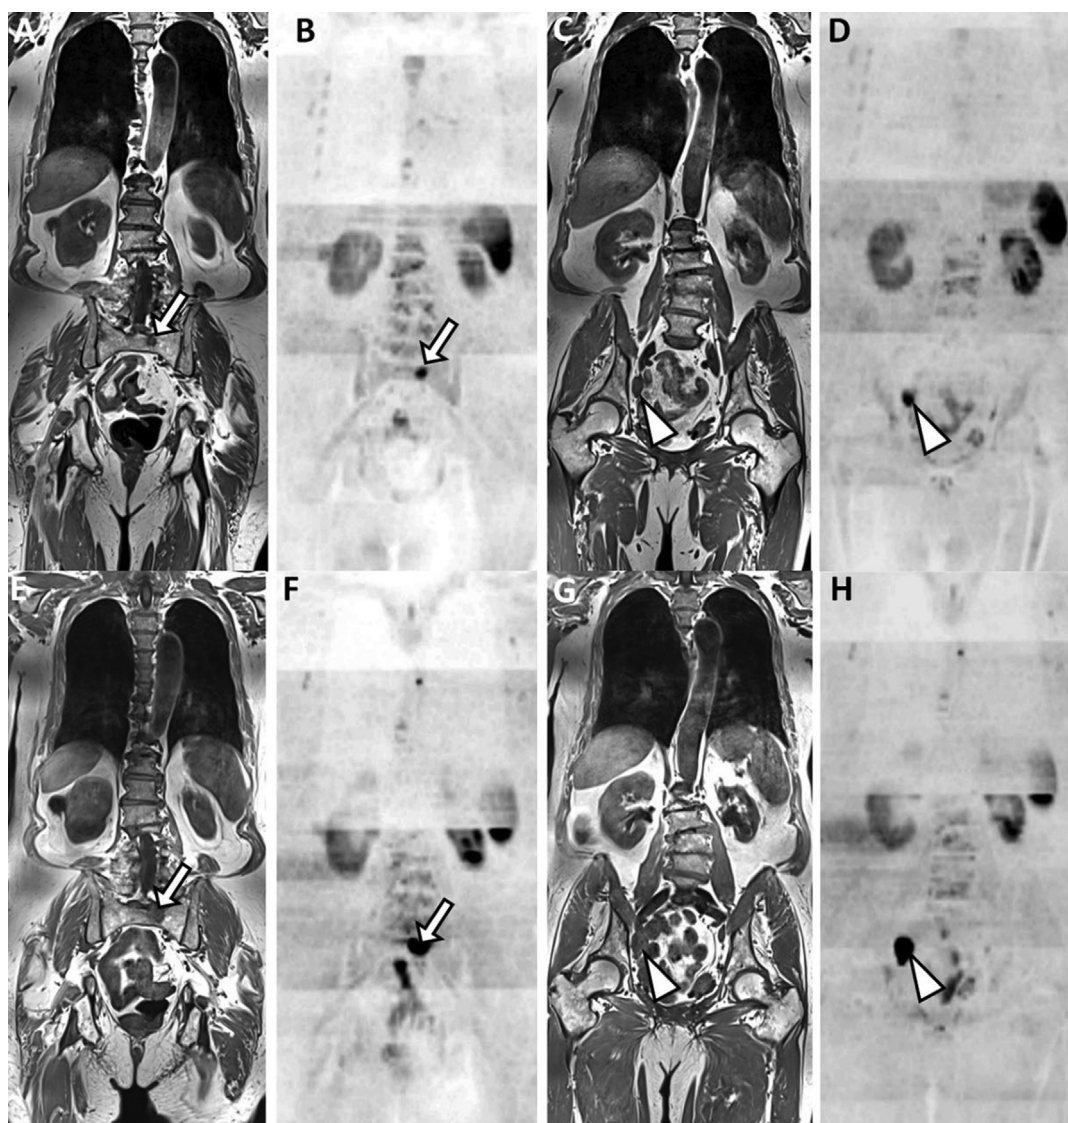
Progression of bone and node metastases in a 77-yr-old man with metastatic hormone-naïve prostate cancer (response assessment category 5). Comparison of whole-body magnetic resonance imaging before and after treatment. (A,C) Coronal T1-weighted images and (B,D) DWI scans ($b = 1000 \text{ s/mm}^2$, inverted gray scale) at baseline show bone metastasis in the sacrum (arrows in A, B), and right iliac node (arrowheads in C, D). Corresponding (E,G) T1-weighted images and (F,H) DWI scans at 6-mo follow-up show progression in the size of metastatic foci. DWI = diffusion-weighted imaging.
